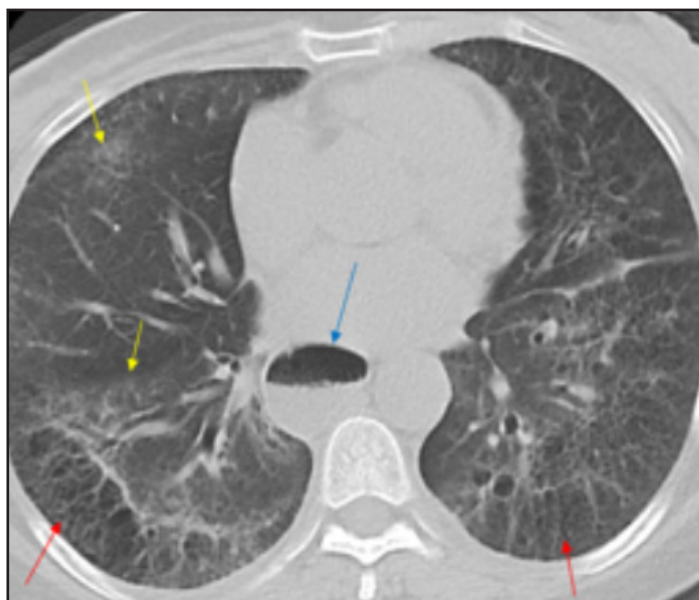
Progressive systemic sclerosis (scleroderma). Axial unenhanced CT image demonstrating common findings of scleroderma including ground-glass opacities (yellow arrows), subpleural and basilar predominant cystic changes (red arrows), as well as esophageal dilation (blue arrow).
